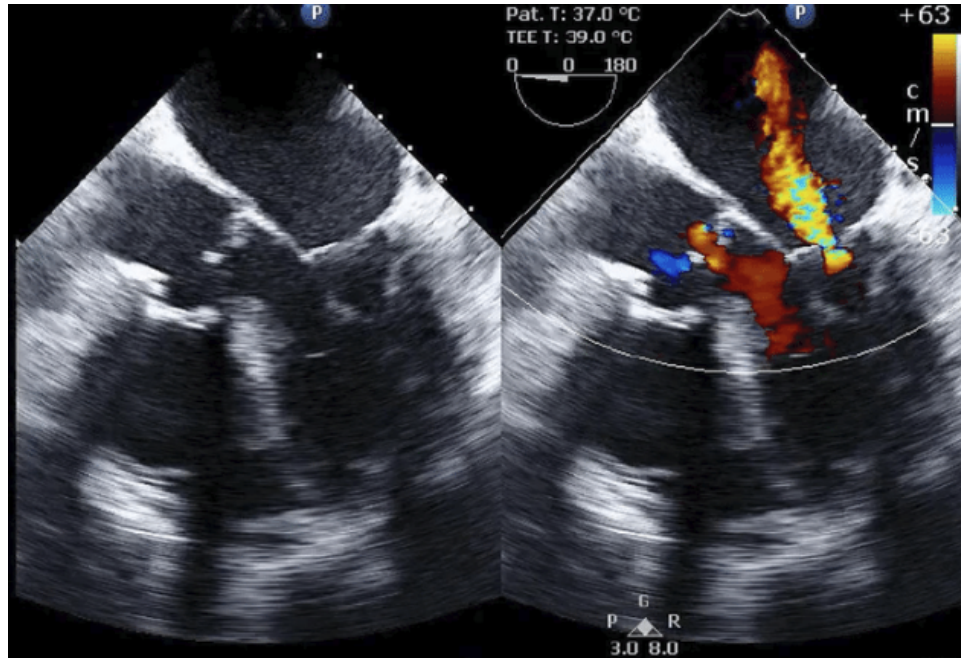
Diagnostic, preoperative TEE images of the mitral valve (left) and color Doppler image (right) depicting mild to moderate functional MVR [47]
